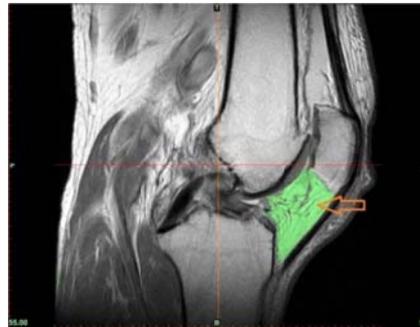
The arrow points the location of the infrapatellar fat pad on sagittal view of a T2 MRI
